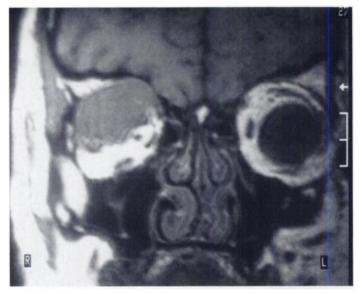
MRI follow-up examination 6.5 wk later. Compare with Figure 1 and note the increase in size of the space-consuming mass.
